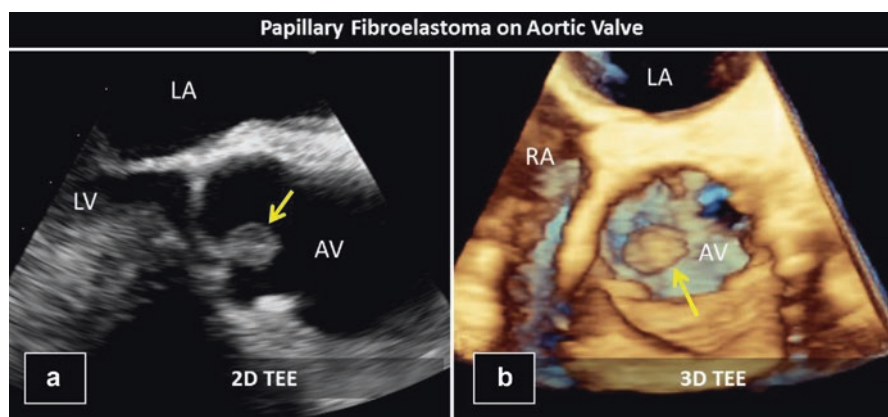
PFE. (a) Papillary fibroelastoma on the aortic side of the aortic valve on two dimensional imaging. (b) PFE visualized on 3-D TEE. LA Left atrium, LV Left ventricle, AV Aortic valve, TEE Transesophageal echocardiogram
